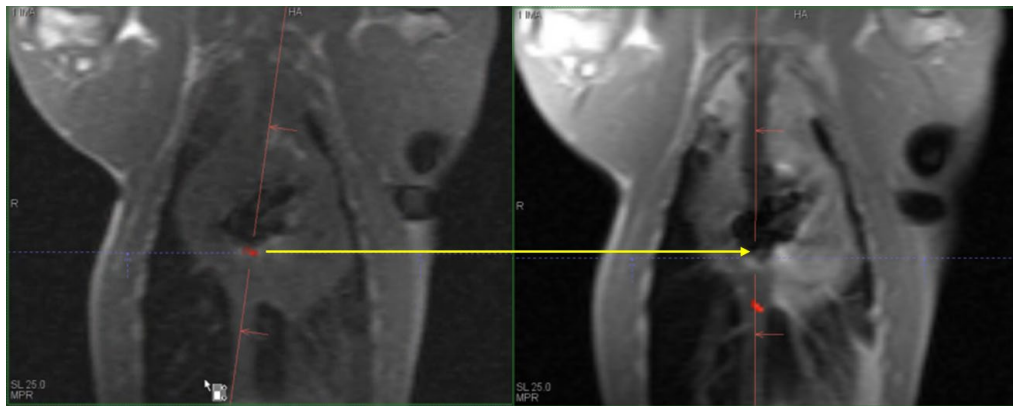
Catheter tracking demonstration: the MRI images show the catheter tip at two different locations.
